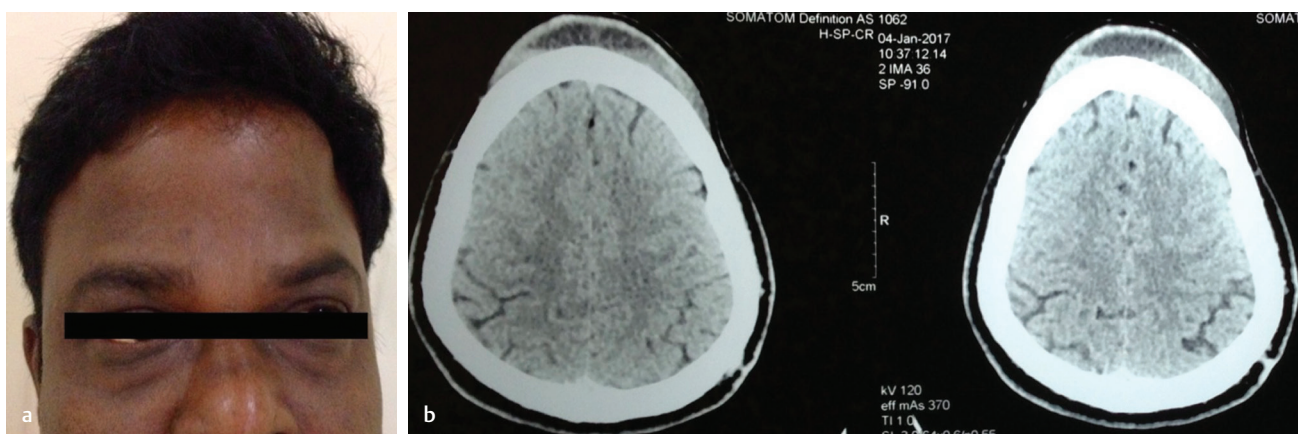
A tense and moderately tender scalp swelling in forehead region (a). Computed tomography of the head showing bifrontal subgaleal heterogeneous fluid collection without skull fracture (b).
